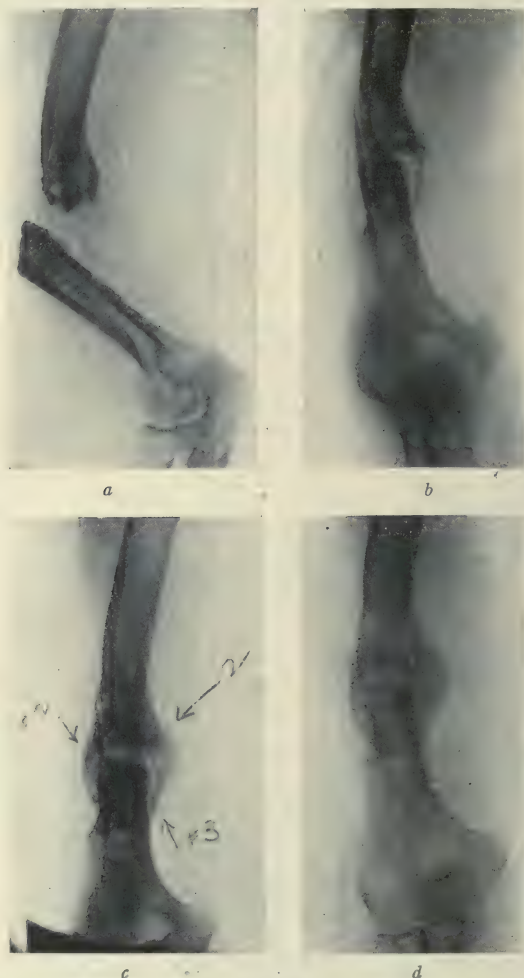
a*, Ununited fracture of the humerus at the junction of the middle and lower thirds, with loss of bone substance. Fracture of three months' duration. On account of the unfavorable nature of the case, a tibial bone-graft was recommended; the patient, however, refused to allow the graft to be removed from the tibia, and hence it was necessary to employ the author's sliding graft. *b*, Six weeks after operation at which a sliding inlay graft 3 inches long was dragged down from the upper into the lower fragment. Slivers of bone were obtained from the upper end of the groove and placed subperiosteally with one half in contact with the upper and one half in contact with the lower fragment. These slivers are shown clearly in position in the x-ray photograph. *c*, X-ray 10 weeks after operation, showing marked osteogenesis from the sliver grafts at the arrow points "2" and "3." *d*, Four months after operation, showing complete consolidation. The active osteogenesis from the external sliver grafts is strikingly well shown in this case.
